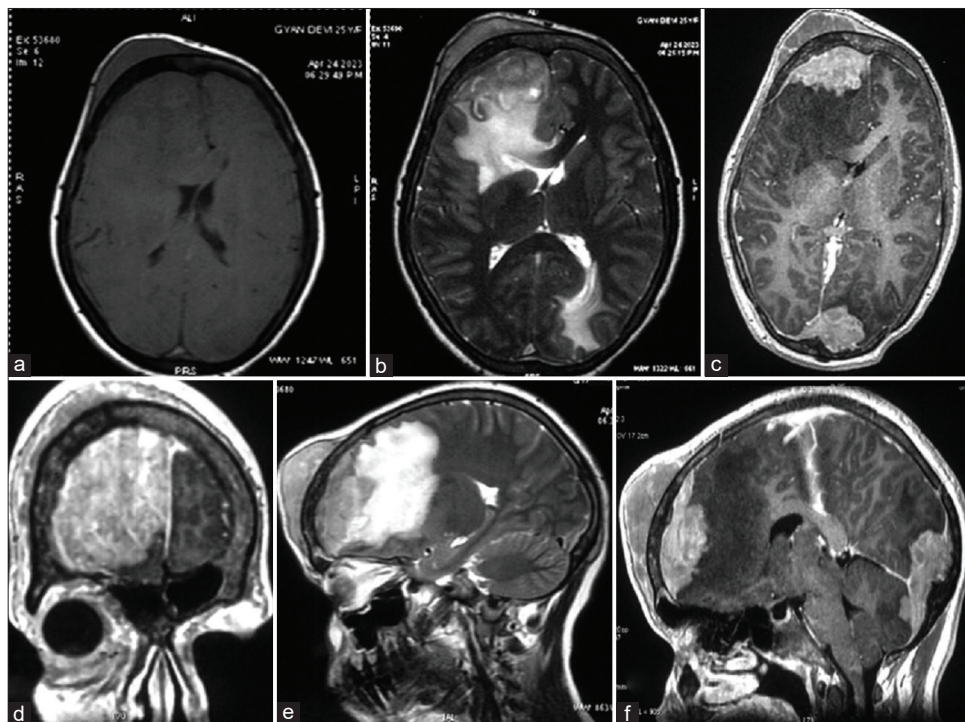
Magnetic resonance imaging brain – (a) T1 axial sequence, (b) T2 axial sequence, (c) T1 C+ axial sequence, (d) T1 C+ coronal sequence, (e) T2 sagittal sequence, and (f) T1 C+ sagittal sequence – showing a T1 hypointense, T2 iso-hyperintense axial lesion in the right frontal region with heterogeneous enhancement with prominent peritumoral vasogenic edema with extension into extracranial space and another similar lesion in the posterior fossa.
